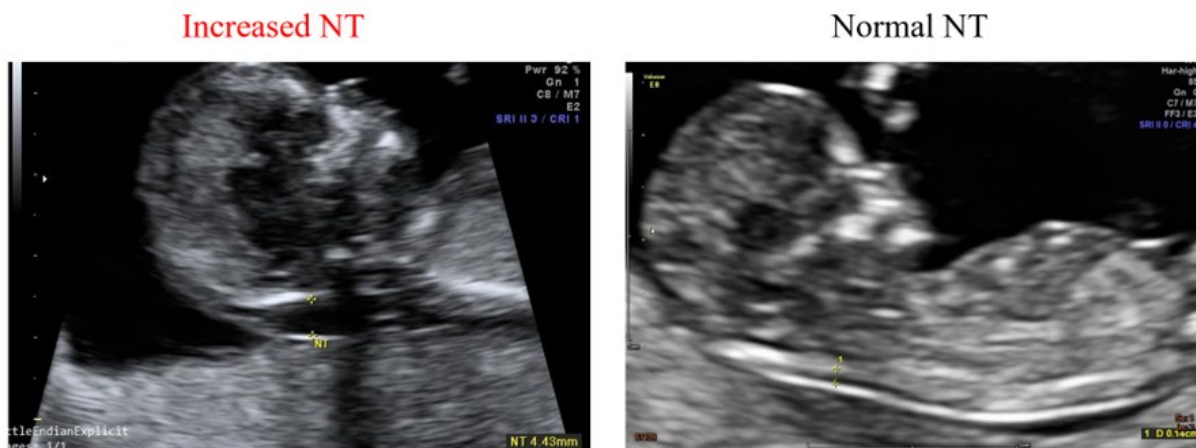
Example of Increased and Normal Nuchal Translucency in First-Trimester Ultrasound Images
